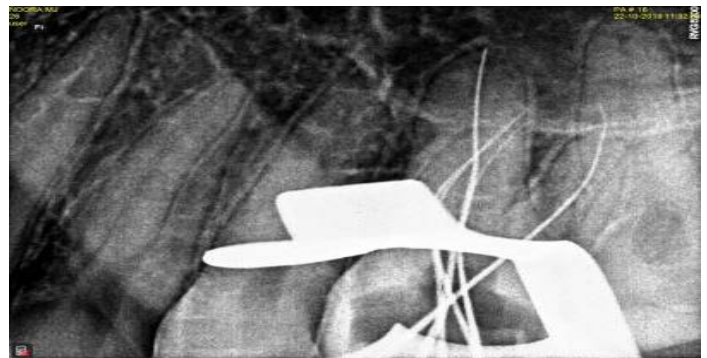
c: Working length radiograph
